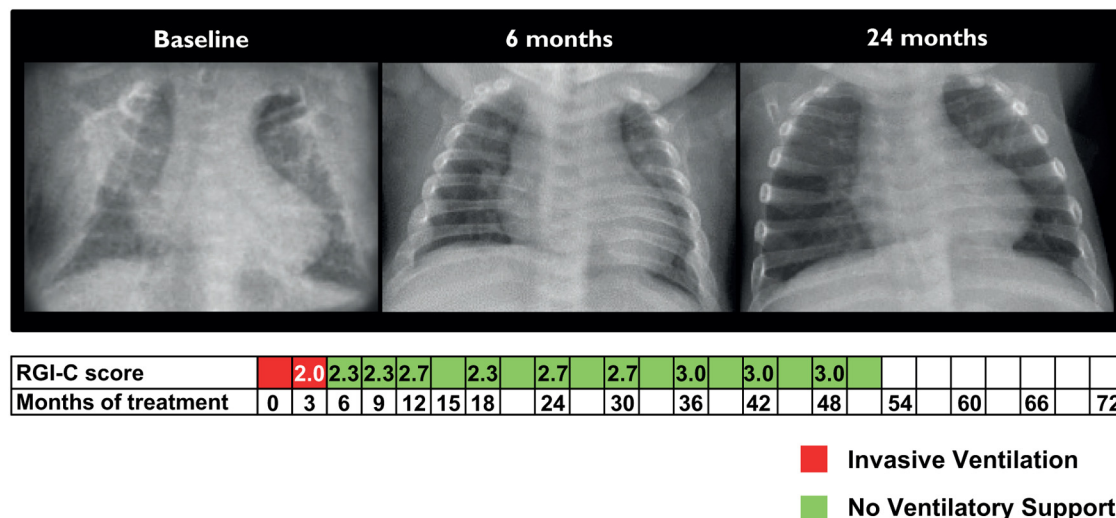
Radiographic changes with asfotase alfa treatment (Patient 10–3). Better rib mineralization, chest structure, and thoracic volume with improved ventilatory status in an infant with hypophosphatasia (5.1 weeks of age at treatment baseline). RGI-C, Radiographic Global Impression of Change scale.
